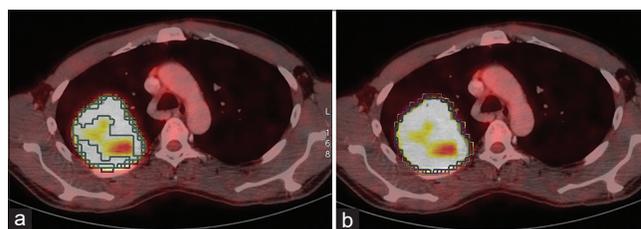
Auto contour delineated using different percentage threshold (a) and absolute SUVs (b). Note in (a), central area of necrosis is left out in 50% threshold auto contour
